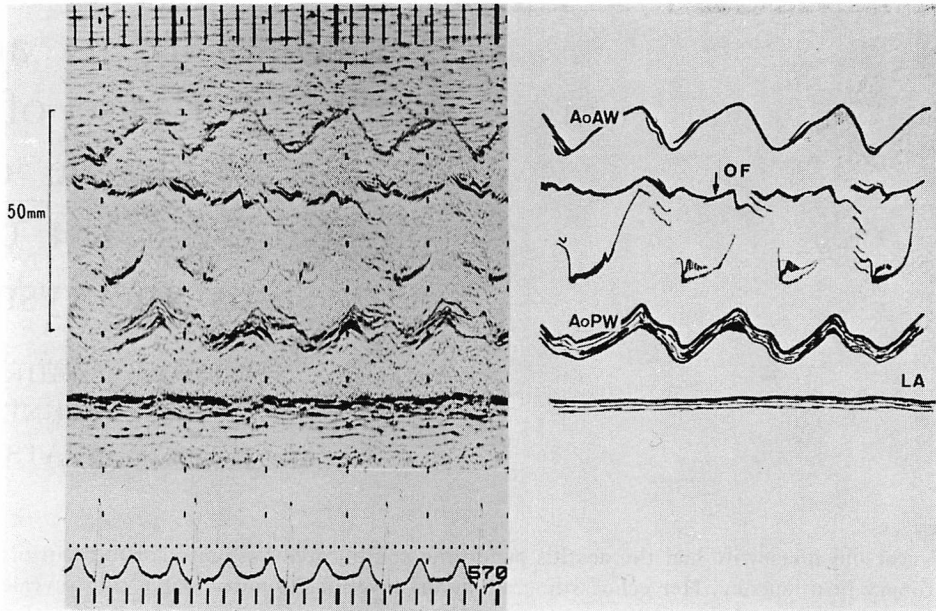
M-mode echocardiogram of the aortic root shows an oscillating flap and a markedly dilated aorta compressing the left atrium.
